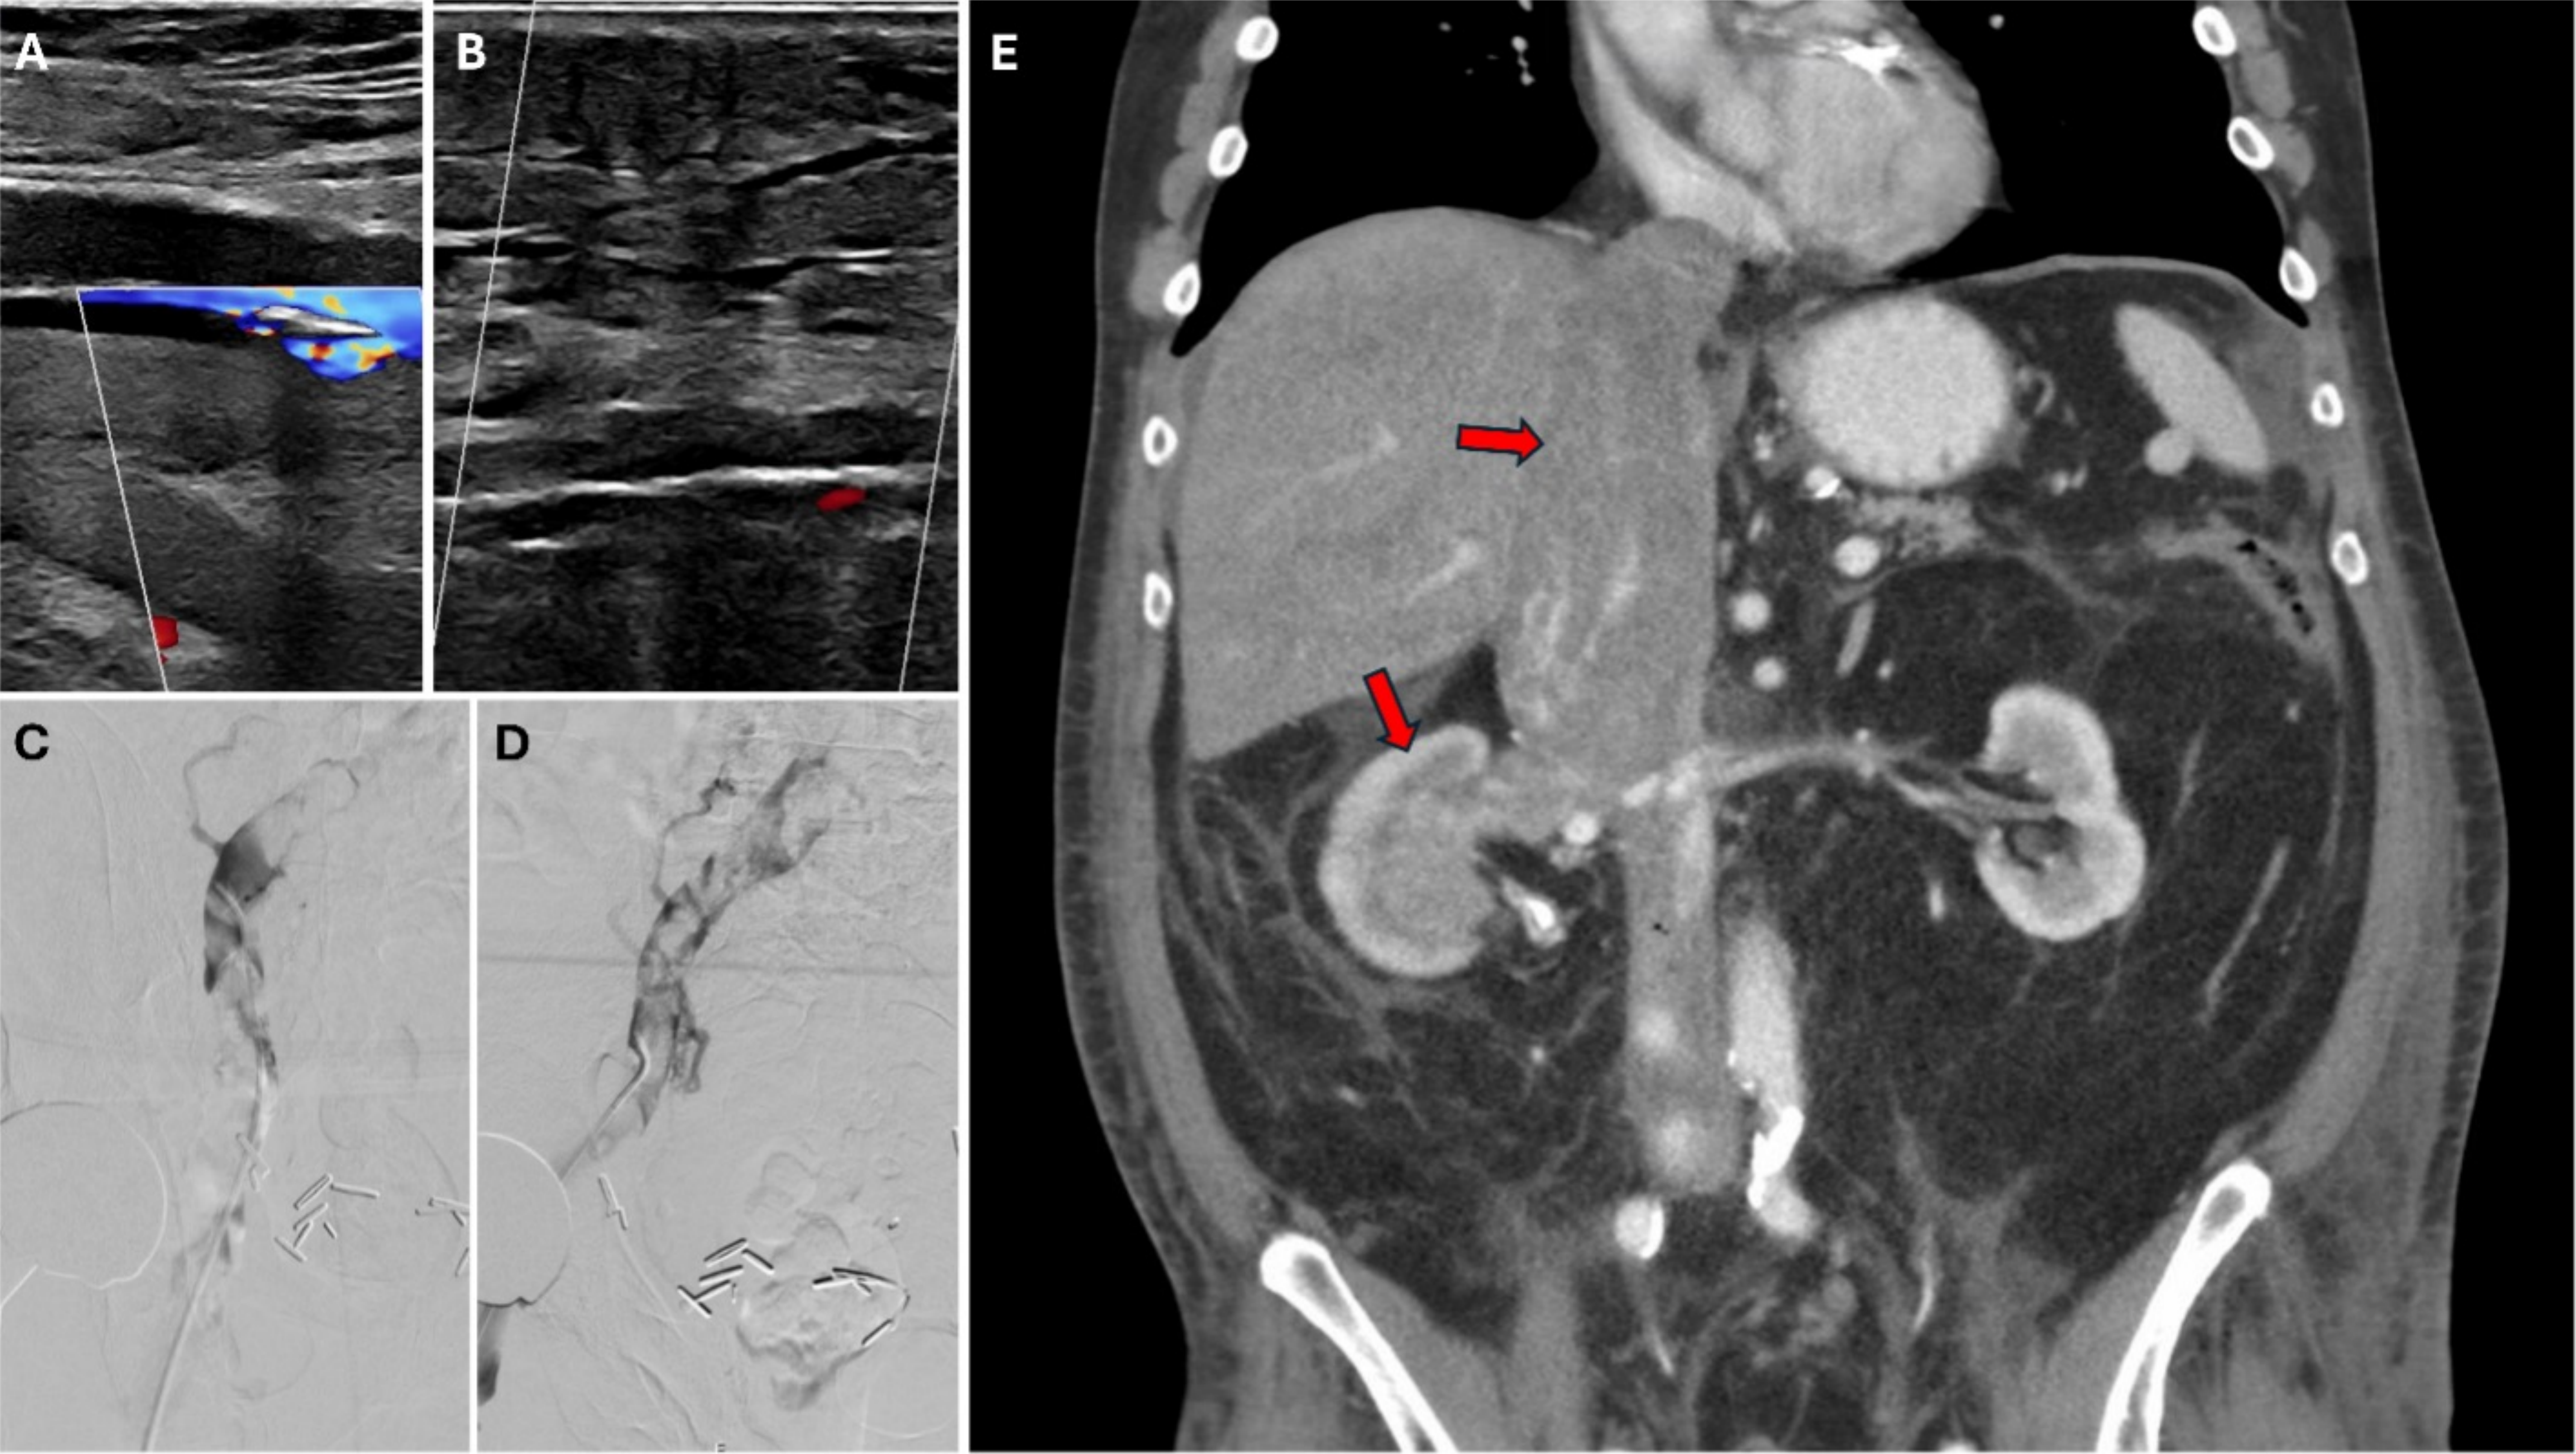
A: Doppler ultrasound of the left common femoral vein bifurcation, demonstrating thrombosis. B: Doppler ultrasound of the left popliteal vein, revealing thrombosis. C: pre-tPA thrombolysis image of external iliac vein. D: post 24 hours tPA thrombolysis revealing remaining clots. E: Coronal view of CT abdomen and pelvis revealing a 5 × 7 × 4.5 cm right renal mass with a tumor thrombus extending into the right renal vein and IVC, reaching the inferior margin of the right atrium.
